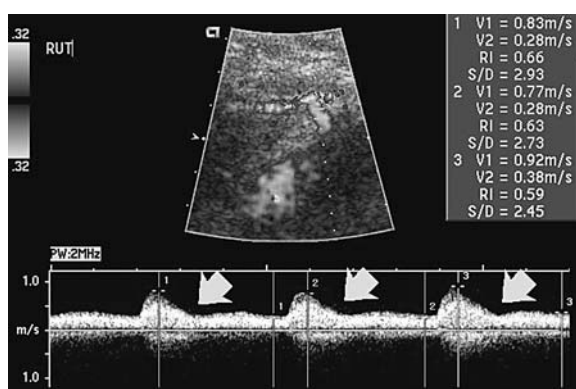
An abnormal uterine artery Doppler wave form at 24 weeks' gestation in a hypertensive patient who later developed superimposed pregnancy-induced hypertension associated with IUGR. The arrows indicate uterine artery "notching"
